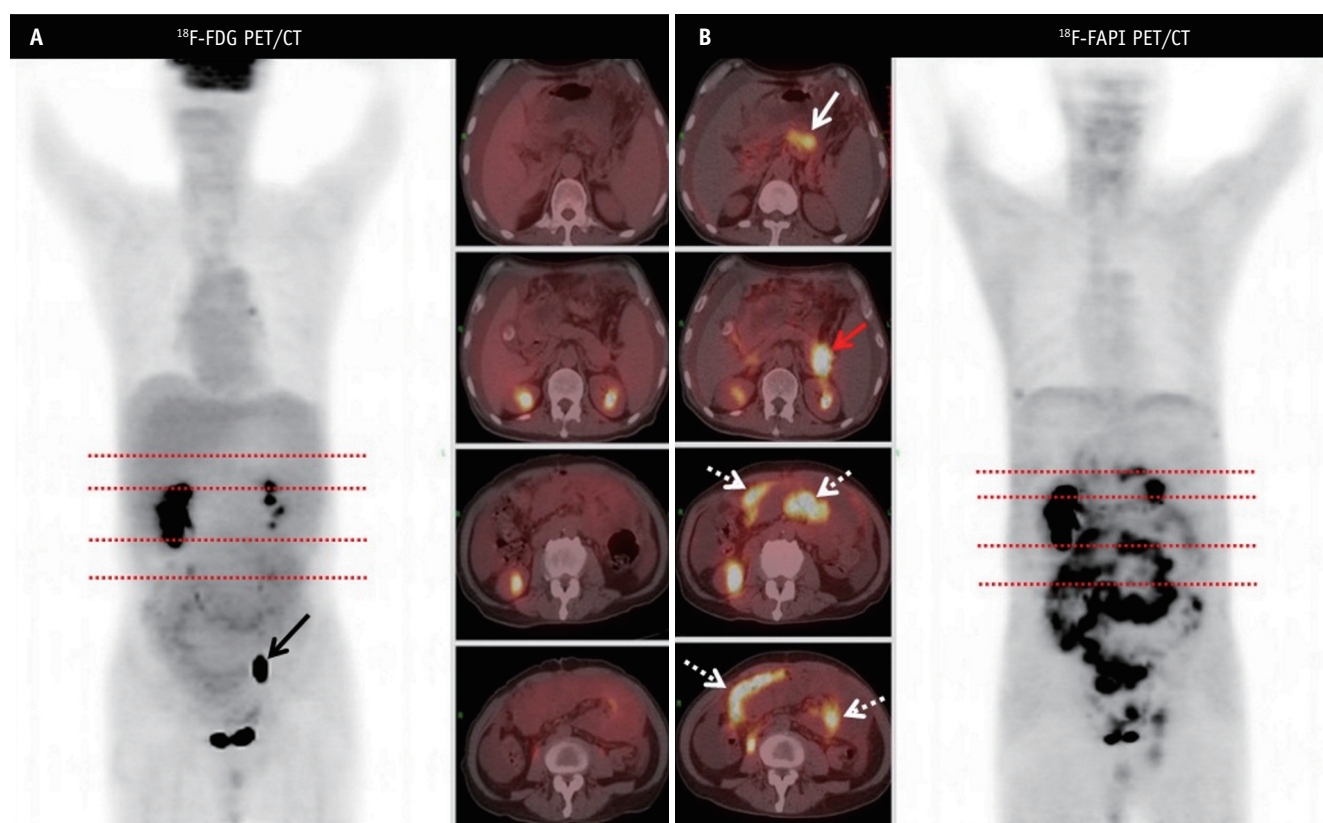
A 65-year-old male presented with abdominal pain and massive ascites. The cytological examination of the ascites revealed mesothelial cell proliferation. The red dashed lines represent the level of each of the fused axial images. A: Images from fluorine 18 (^{18}F) fluorodeoxyglucose (FDG) PET/CT show diffuse radioactive uptake in the mesentery and greater omentum, but ^{18}F -FDG uptake is weak in all the lesions (SUVmax2.82). Intrapelvic hypermetabolic foci is a physiological radioactive accumulation of left ureteral urine (black solid arrow) (left image: anterior maximum intensity projection image from ^{18}F -FDG PET; right images: axial fused PET/CT images). B: Images from 18 (^{18}F) fibroblast-activation protein inhibitor (FAPI) PET/CT show intense tracer uptake in the primary lesion of the pancreatic tail (red solid arrow, SUVmax9.55), the lesser curvature of the stomach (white solid arrow, SUVmax4.85) as well as the mesentery and greater omentum (dashed arrows, SUVmax6.46) (right image: anterior maximum intensity projection image from ^{18}F -FAPI PET; left images: axial fused PET/CT images). PET/CT = positron emission tomography/computed tomography, SUV = standard uptake value
